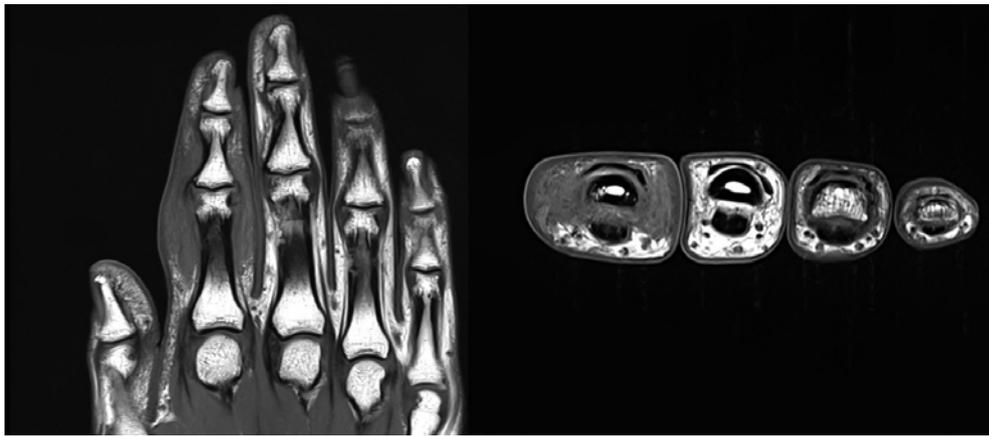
In magnetic resonance imaging, an infiltrative soft tissue lesion was observed on the radial and ulnar sides of the proximal interphalangeal (PIP) joint of the right second finger. On T1-weighted images, the lesion demonstrated homogeneous isointensity relative to muscle.
